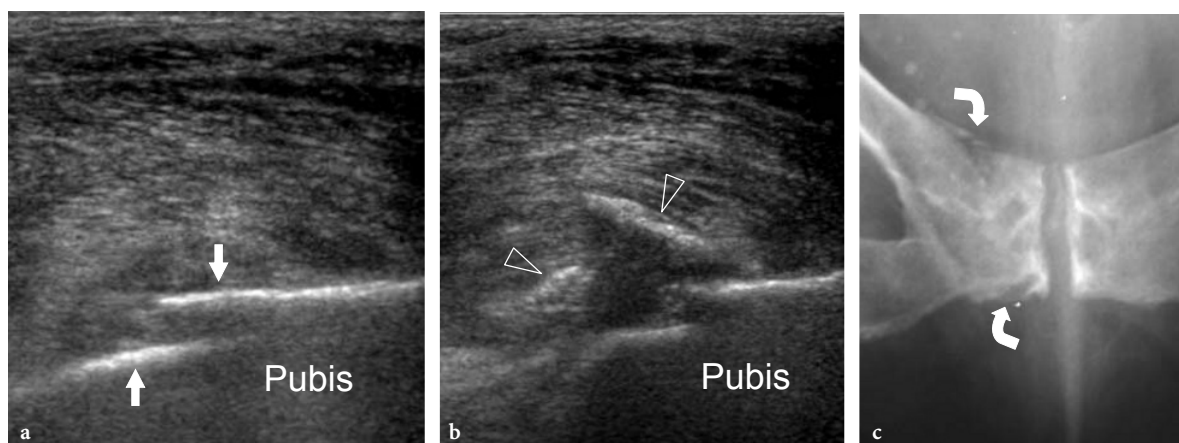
Fracture of the pubis. a,b Sagittal 12–5 MHz US images obtained in a middle-aged woman presenting with persistent groin pain after a fall show a discontinuity (*arrows*) of the bright echogenic line of the bony cortex of the right pubis and elevation of some fragments of bone (*arrowheads*) consistent with a fracture. c After US examination, the patient was submitted to a radiographic study which confirmed the fracture (*curved arrows*) of the pubis
